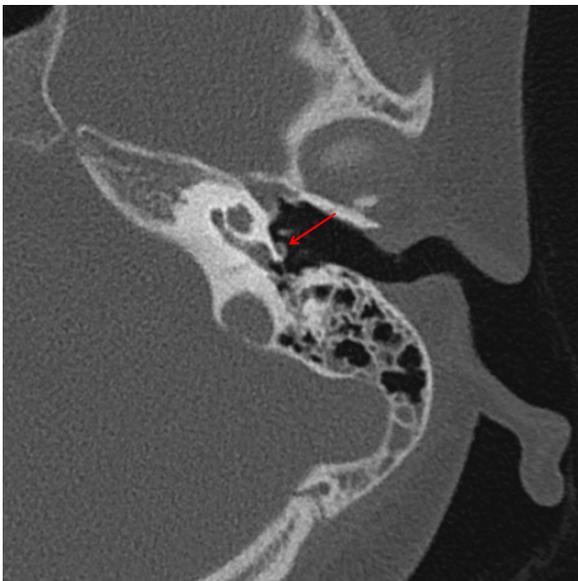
Axial CT scan of the left temporal bone showing persistence of the left stapedia artery. Red arrow: persistent stapedia artery.
